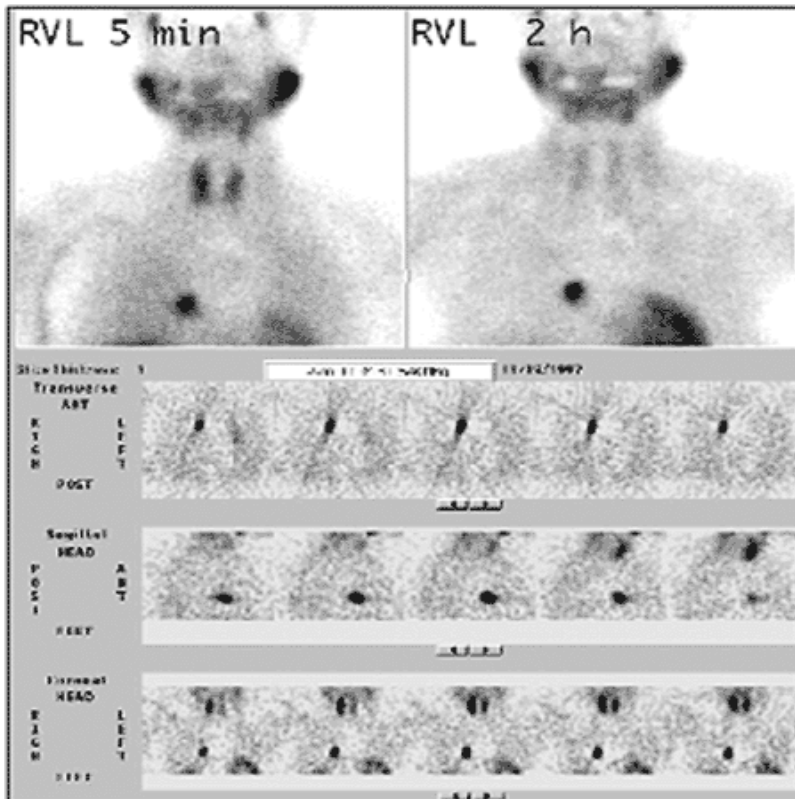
Tc-99m MIBI examination in a patient with an intrathoracic parathyroid gland adenoma in planar technique (above) and in SPECT technique (below) with the E.CAM.
